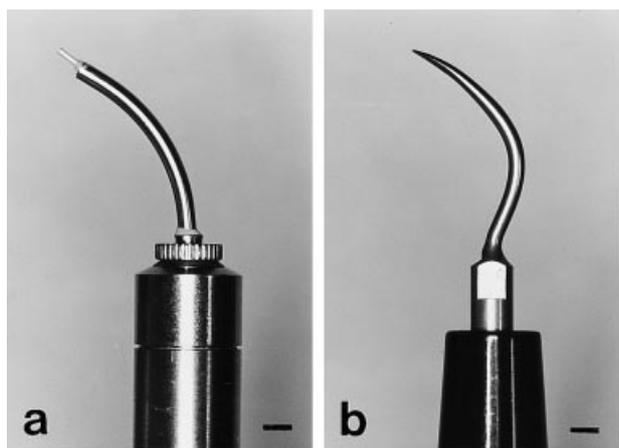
Tips used for the scaling. (a) Er:YAG laser contact tip; 80-degree curved contact tip for ErwinTM apparatus, having a diameter of 600 μm and approximately 65% laser transmission. (b) Ultrasonic scaler tip; universal tip with a sharp point for SolfyTM apparatus. Original magnification: $\times 2$. Bar = 3 mm.
